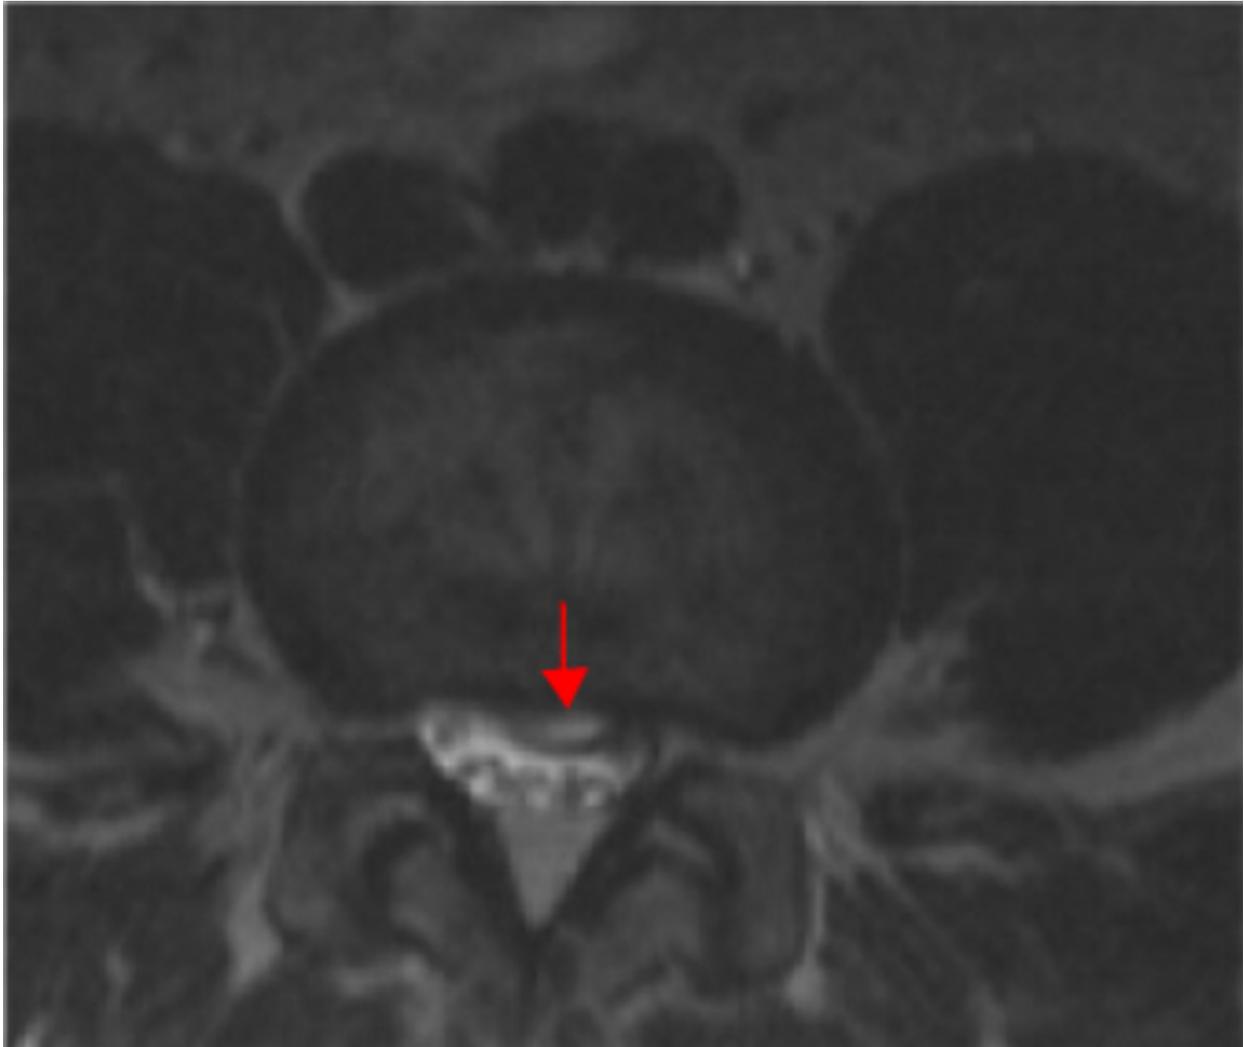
Axial T2 Weighted Lumbar Spine MRI image showing Left Central Disc Herniation
